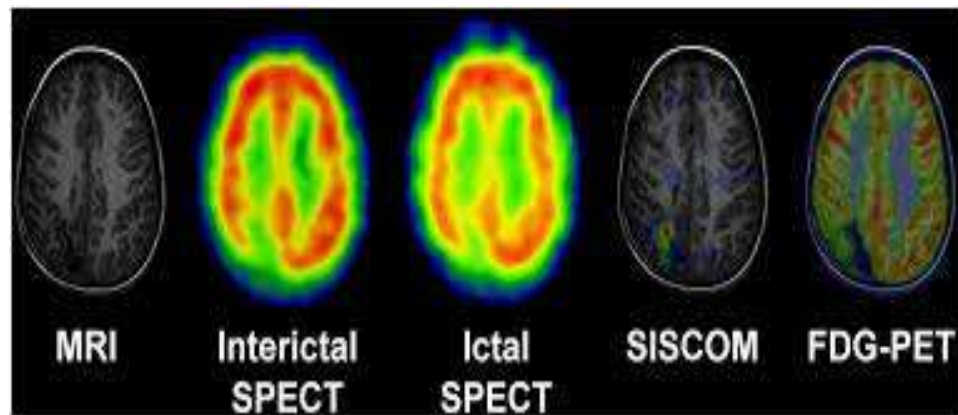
Subtraction ictal SPECT Co-Registered to MRI (SISCOM)
